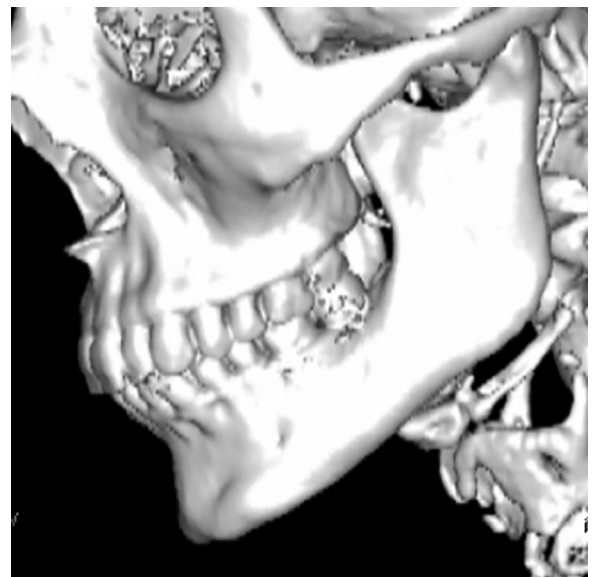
Preoperative three-dimensional computed tomography scan.
